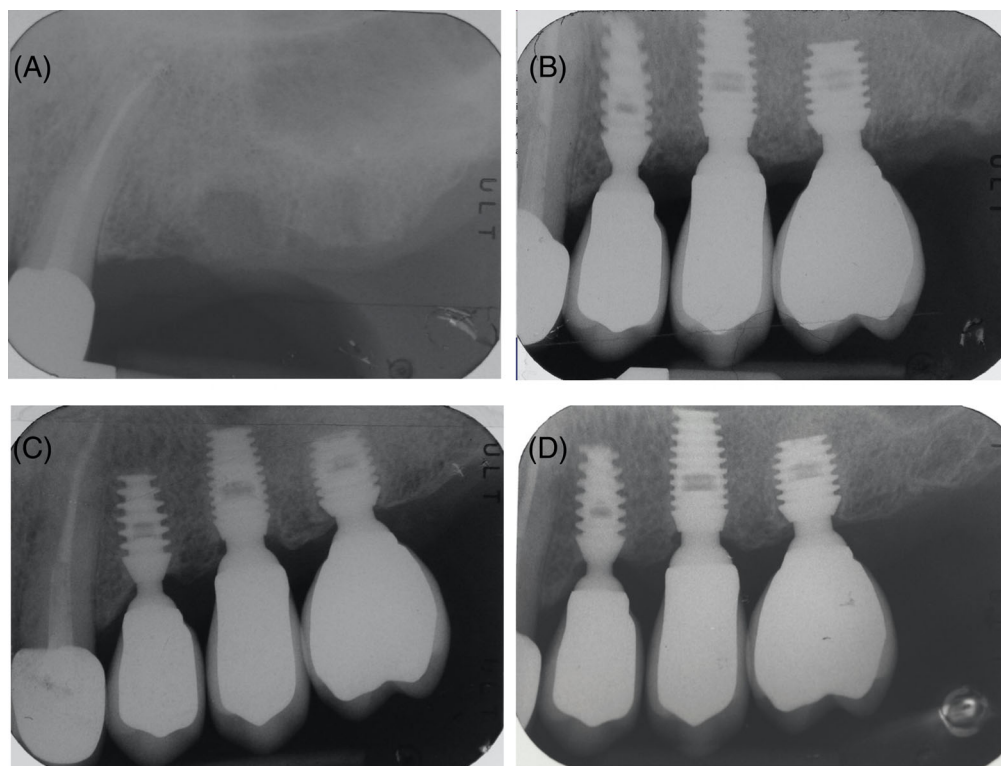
Single implants placed in 2.4, 2.5, and 2.6 sites (4 × 8 mm, 4.5 × 8 mm, and 5 × 6 mm): (A) Preoperative radiograph before implants placement; (B) radiograph obtained at time of loading; (C) radiograph obtained at 3-year follow-up; (D) radiograph obtained at 5-year follow-up
